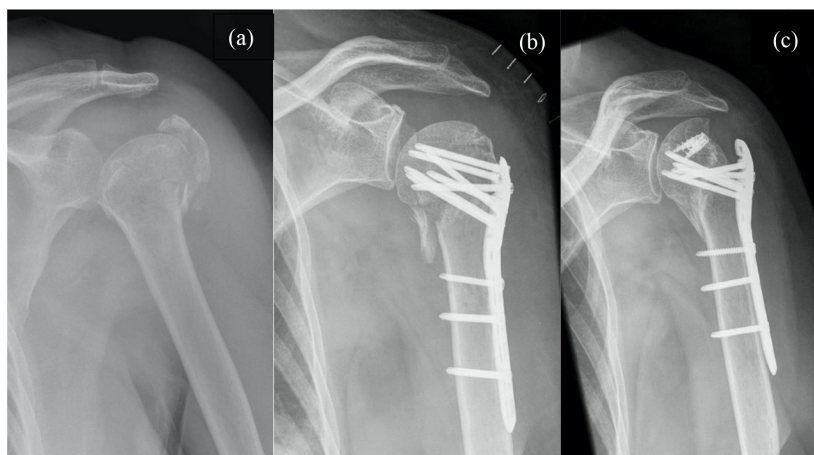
Proximal humerus surgical neck valgus fracture and a greater tuberosity fracture (3-part fracture). (a)—fracture x-ray on the day of the injury, (b)—open reduction and fixation with locking plate, (c)—revision surgery—removal of proximal locking screws and fixation of rotator cuff tendons with suture anchors, after a complete resorption of the greater tuberosity (right).
